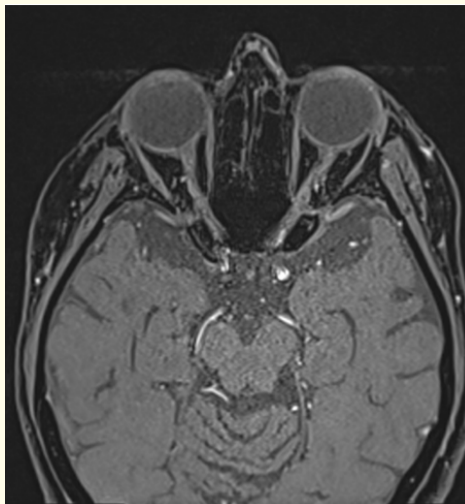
MRI T1weighted images with fat suppression demonstrating bilateral optic atrophy with decreased in its diameter.
